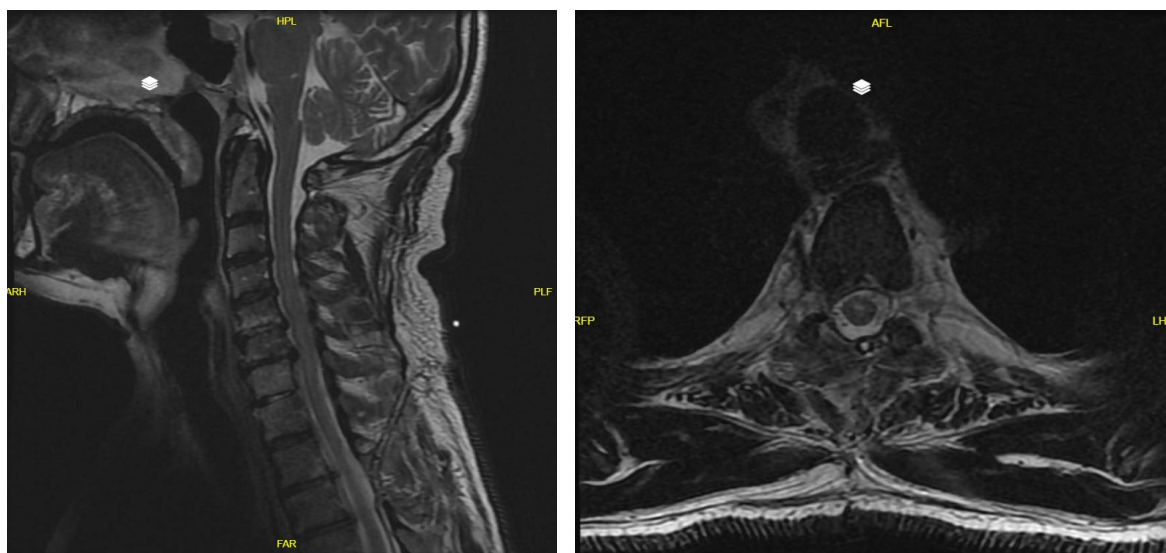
Resolved abscess in T2-weighted sagittal on the right and T2-weighted axial
